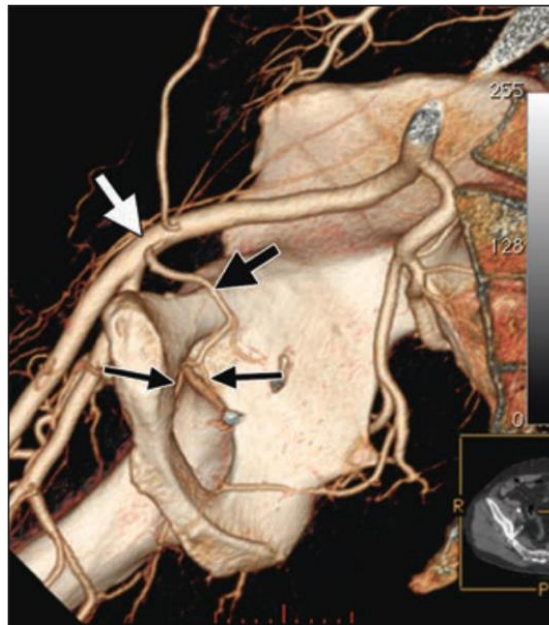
The obturator artery has an abnormal origin, as seen in this 3D volume-rendered reformat CT angiography. The external iliac artery gives rise to the obturator artery (thick black arrows), which divides into internal and exterior muscle branches (thin black arrows) (74).
